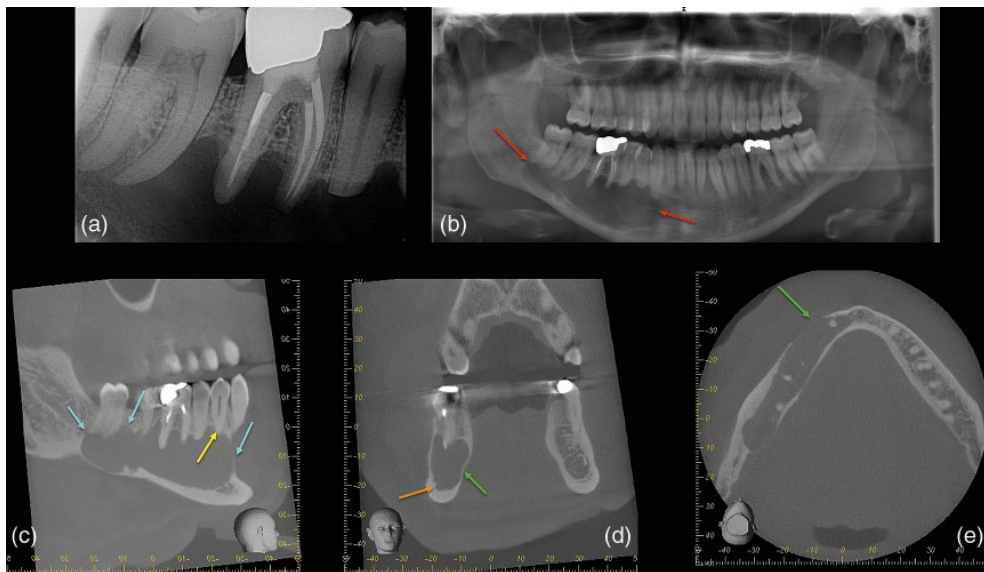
Odontogenic keratocyst. (a) Periapical radiograph reveals a large radiolucency associated with the lower right premolar and root treated molar teeth. (b) Dental panoramic tomograph reveals the extent of the lesion (red arrows). (c–e) Sagittal, coronal and axial reconstructed CBCT slices reveal a large well-defined pseudo-loculated radiolucency in the body of the right mandible extending from lower right incisor to the retromolar, which rises up between the roots. There are signs of external inflammatory resorption associated with the lower right premolar teeth, but not with the root-canal-treated lower right first molar tooth, indicating that the lesion is not inflammatory. The lesion has resulted in thinning out and buccal expansion of the cortices (green arrow), and is in close proximity to the inferior dental nerve (orange arrow).
